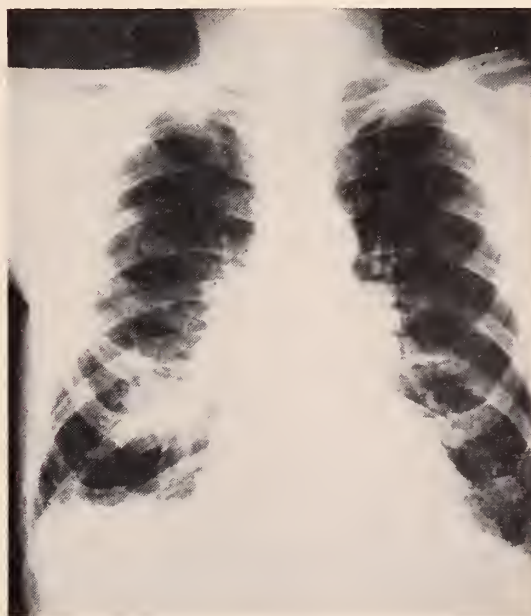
Roentgenogram, March, 1972, tumor in posterior basal segment of right lower lobe.
